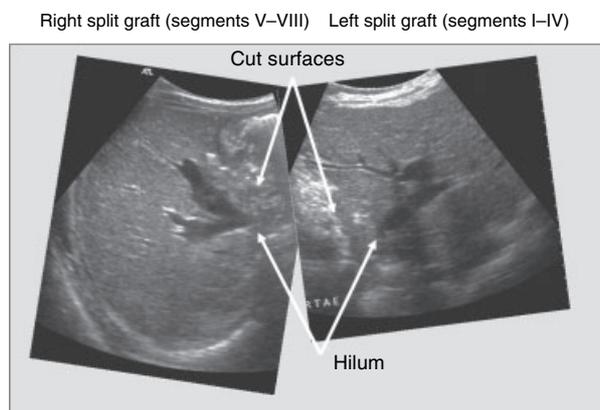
Abdominal ultrasound image of the two children 4 weeks post-transplant.
